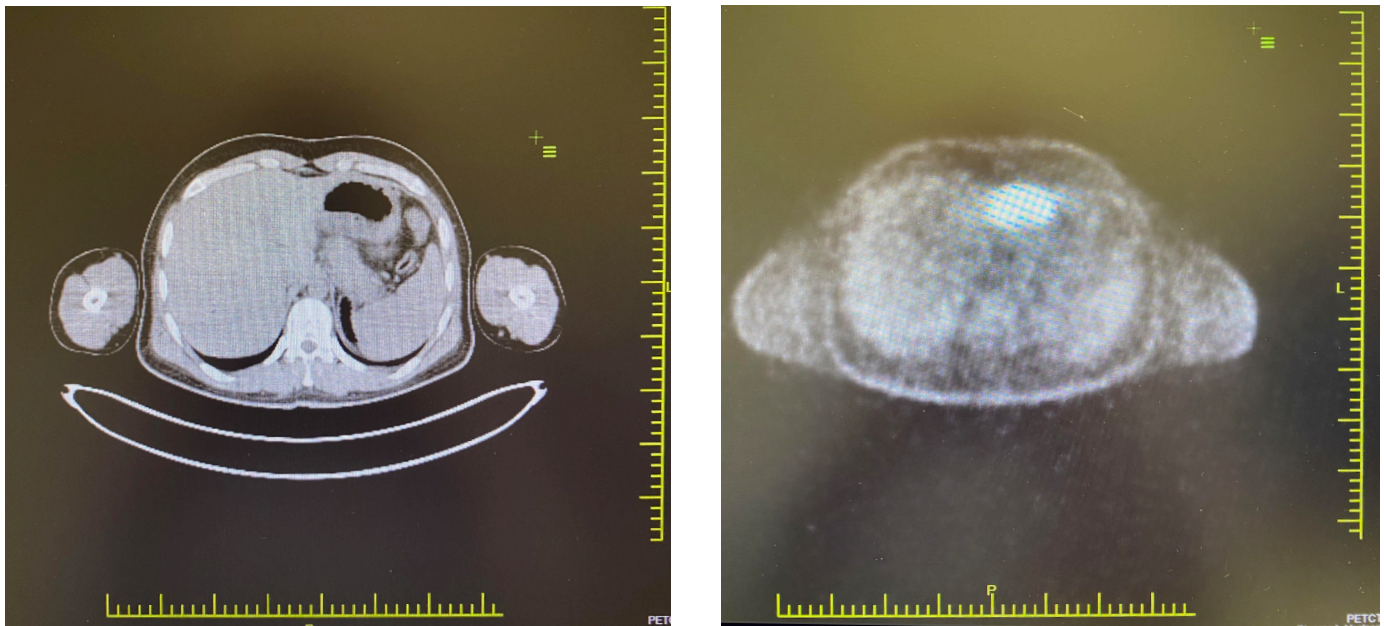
In PET-CT, intensely increased F-18 FDG uptake (SUV max: 12.49) was detected in the area extending to the lumen with a soft tissue density of approximately 4 cm in the small curvature-antrum localization of the stomach.
